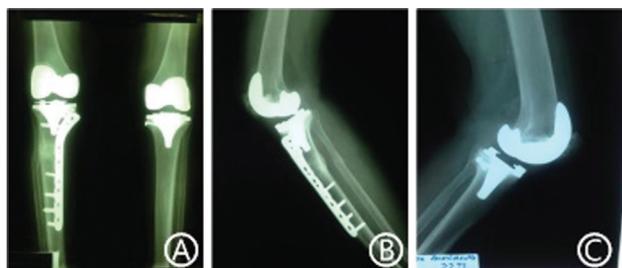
(A) Anteroposterior radiography of the two total knee arthroplasties performed in the patient. Notice the atypical fracture already consolidated. (B) Radiography in profile of the right knee evidencing the consolidation of the atypical fracture also in profile. (C) Radiography in profile of the left knee.
